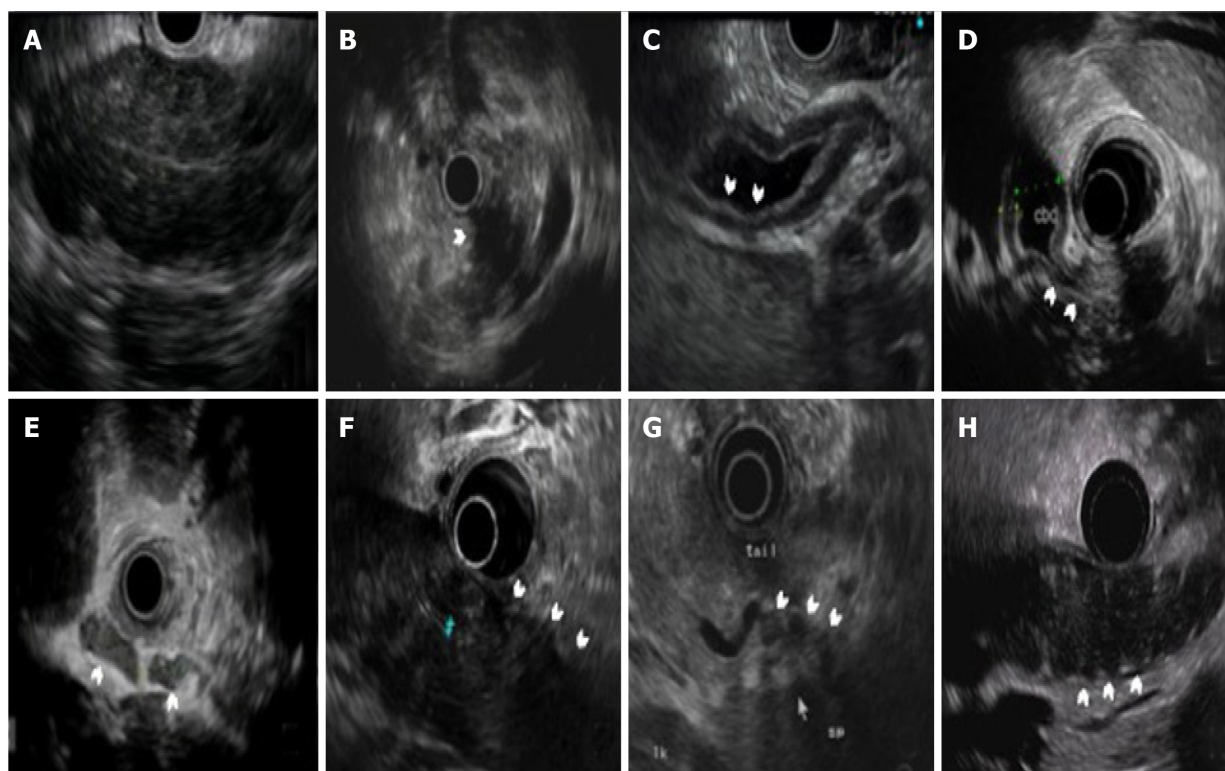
The typical endoscopic ultrasound findings in autoimmune pancreatitis. The white arrows show the following: A: Diffuse hypoechoic area of the pancreatic body; B: Focal hypoechoic area of the pancreatic body; C: Thickened wall of the common bile duct; D: Intrapancreatic bile duct stenosis; E: Peripancreatic lymphadenopathy; F: Peripancreatic hypoechoic margin; G: Peripancreatic vessel involvement with stenosis of the splenic vein; H: Lobular outer margin.
